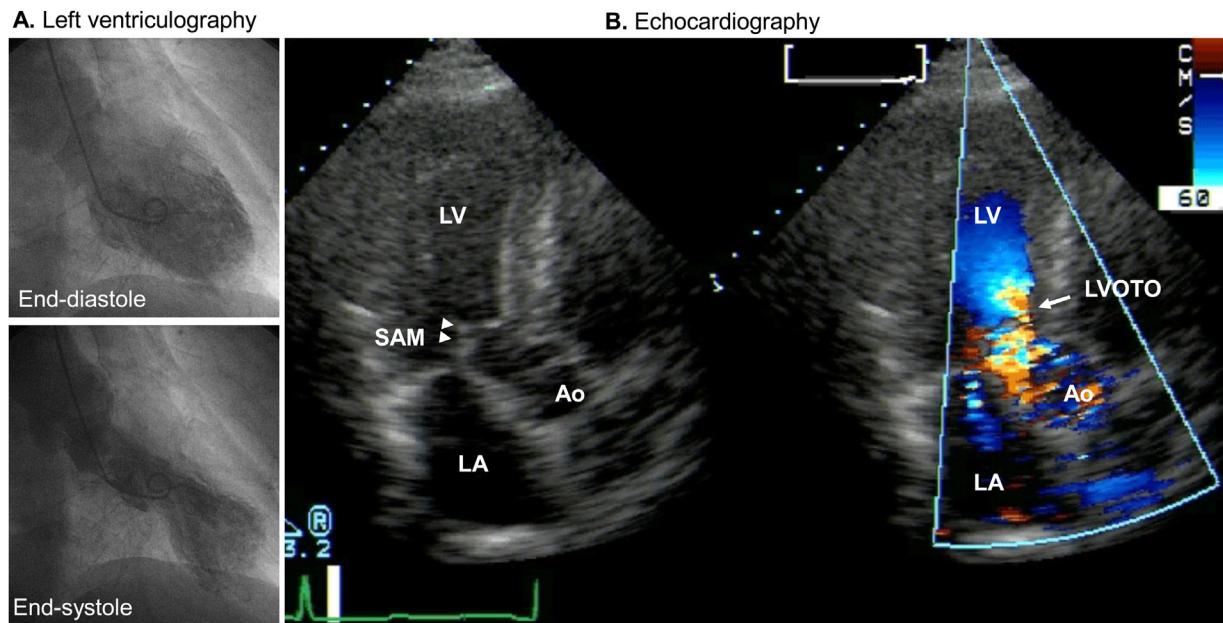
Left ventricular outflow tract obstruction (LVOTO) in takotsubo syndrome. (A) Left ventriculography shows apical ballooning. (B) Echocardiography shows LVOTO (arrow) and mitral regurgitation caused by systolic anterior motion (SAM) of the anterior mitral valve (arrow heads). Ao, aorta; LA, left atrium; LV, left ventricle.
